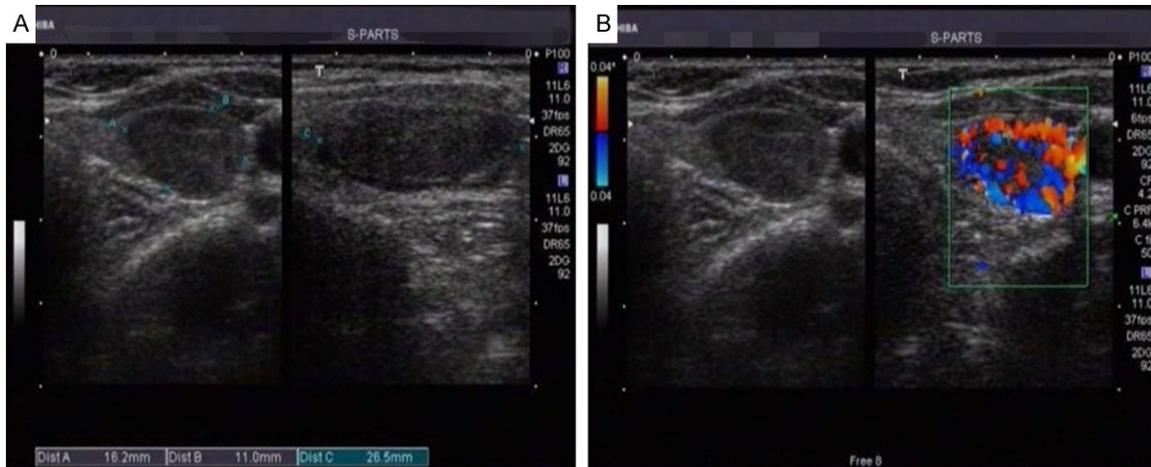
US image data of TC patients. A male patient aged 54 years old. A: An approximately 0.9×0.4 cm hypoechoic nodule is detected at the position near the isthmus of right thyroid gland, the internal echo is not homogeneous, and the boundary is clear and regular. B: Fairly abundant blood flow signals are visible in color Doppler flow image (CDFI), dominated by the peripheral regions and displaying encircled features. The internal echo of the thyroid parenchyma around the nodule is homogeneous.
